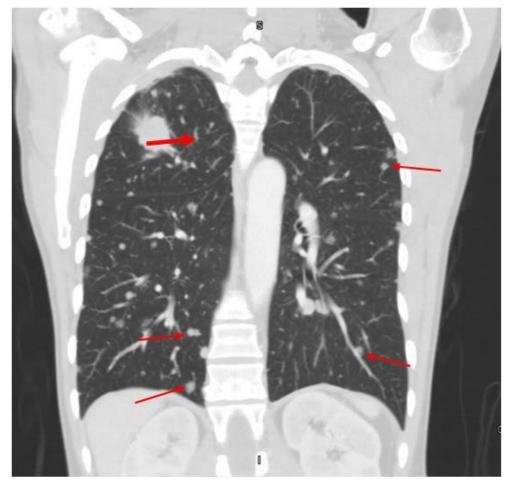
CT of the chest showing a malignant right upper lobe mass and bilateral pulmonary nodules on coronal view
